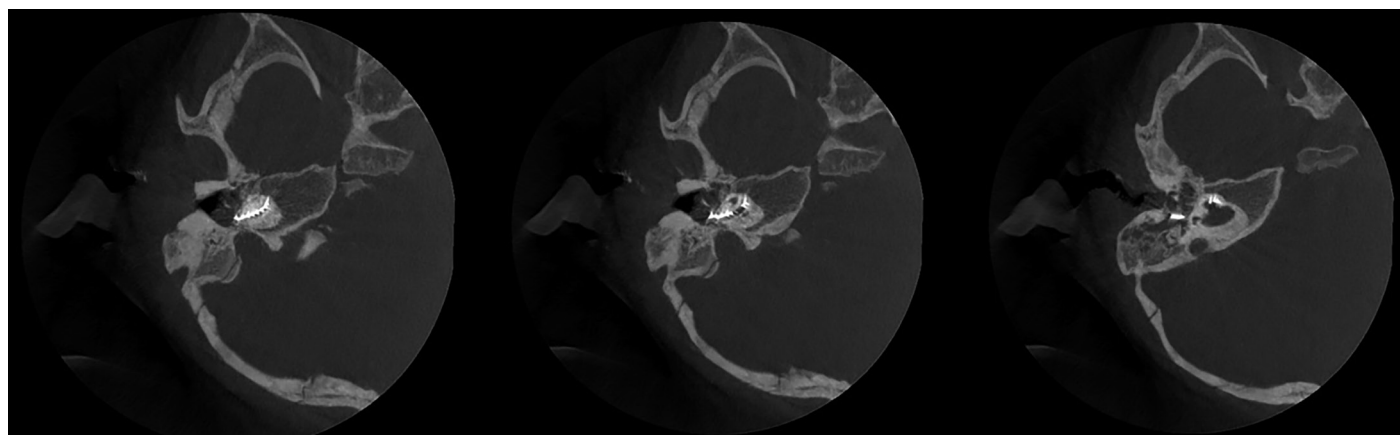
Axial view CT: electrodes within the cochlea after revision surgery.
